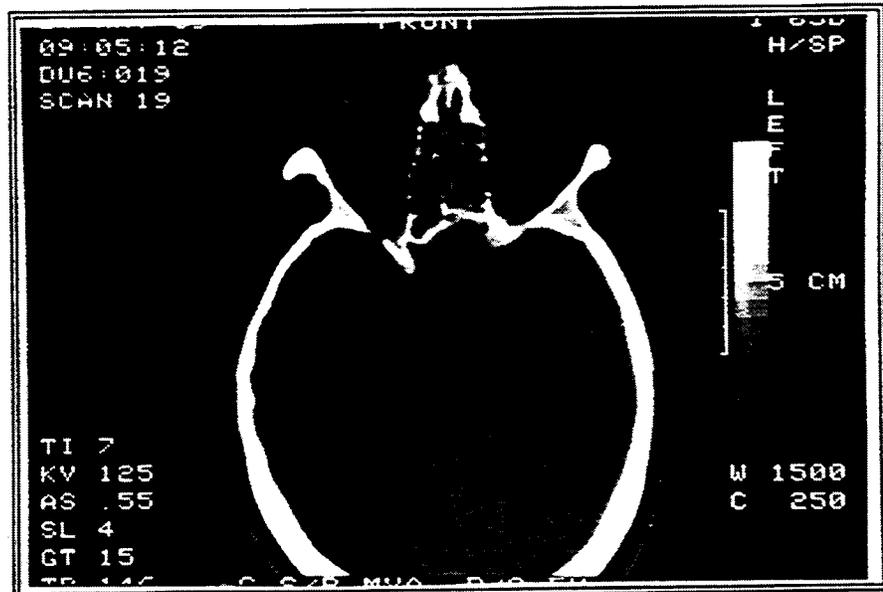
CT Scan Horizontal Section of Head
